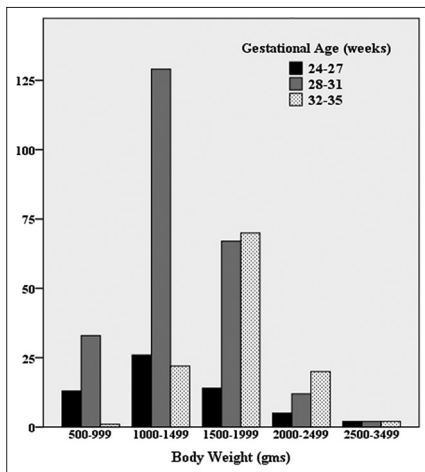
Number of echocardiograms for preterm babies by body weight and gestational age
